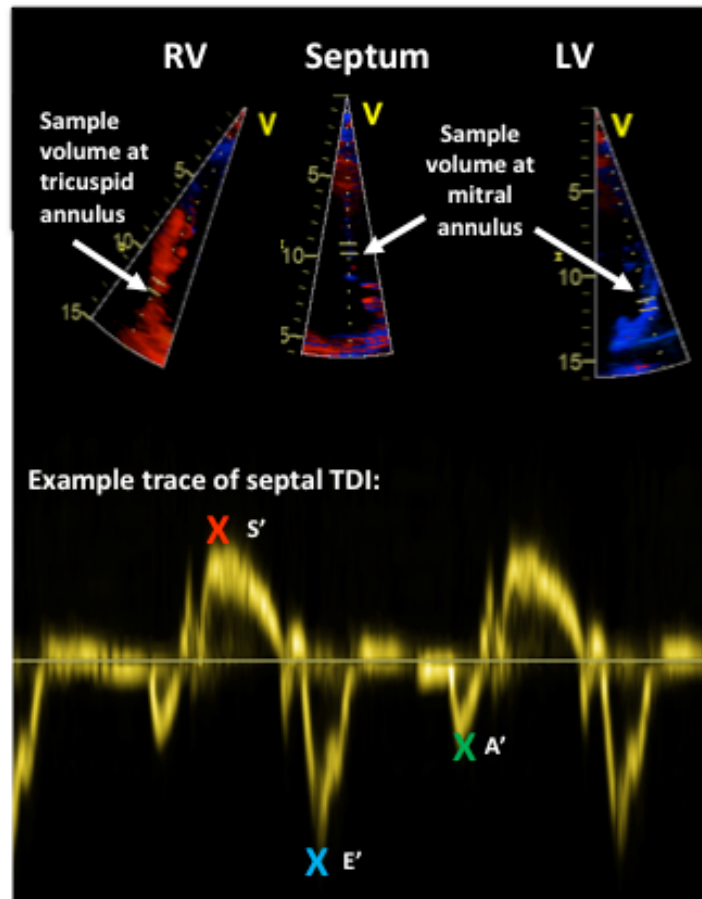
Tissue Doppler imaging (TDI) of the right ventricle (RV), septum and left ventricle (LV) to measure myocardial displacement velocities across the cardiac cycle. Peak systolic (S'), early (E') and late (A') diastolic velocities are measured at the valve annulus on each wall.
